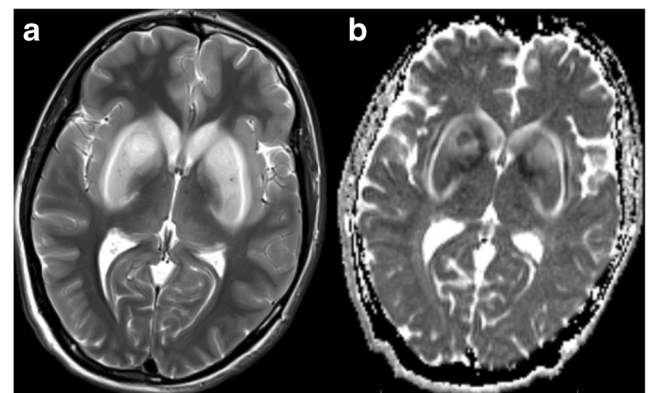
A 16-year-old patient previously treated for streptococcal pharyngitis presenting unarousable. MRI obtained at admission demonstrates extensive involvement of the basal ganglia particularly at the level of the dorsal striatum on T2-weighted images (a) and mixed cytotoxic/vasogenic edema on ADC map (b). The external capsules demonstrate facilitated diffusion consistent with vasogenic edema while the claustrum demonstrates restricted diffusion consistent with cytotoxic edema
